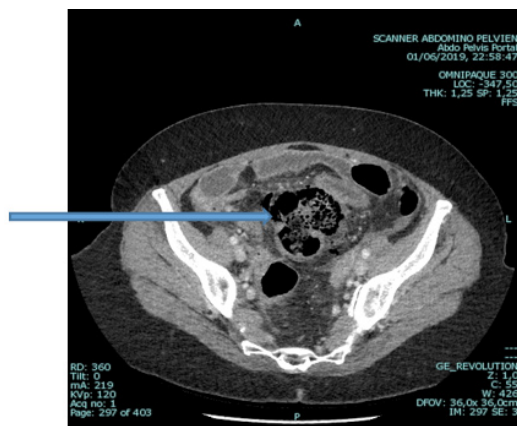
CT scan showing perforation of the sigmoid colon due to impact fecaloma (Blue arrow).
